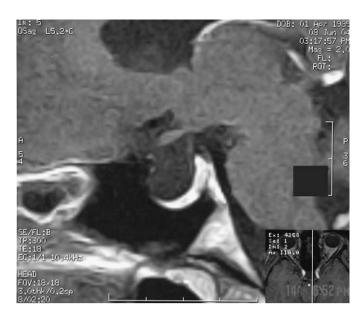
Sagittal T_1 -weighted MRI scan of the empty sella before operation (case 3).
